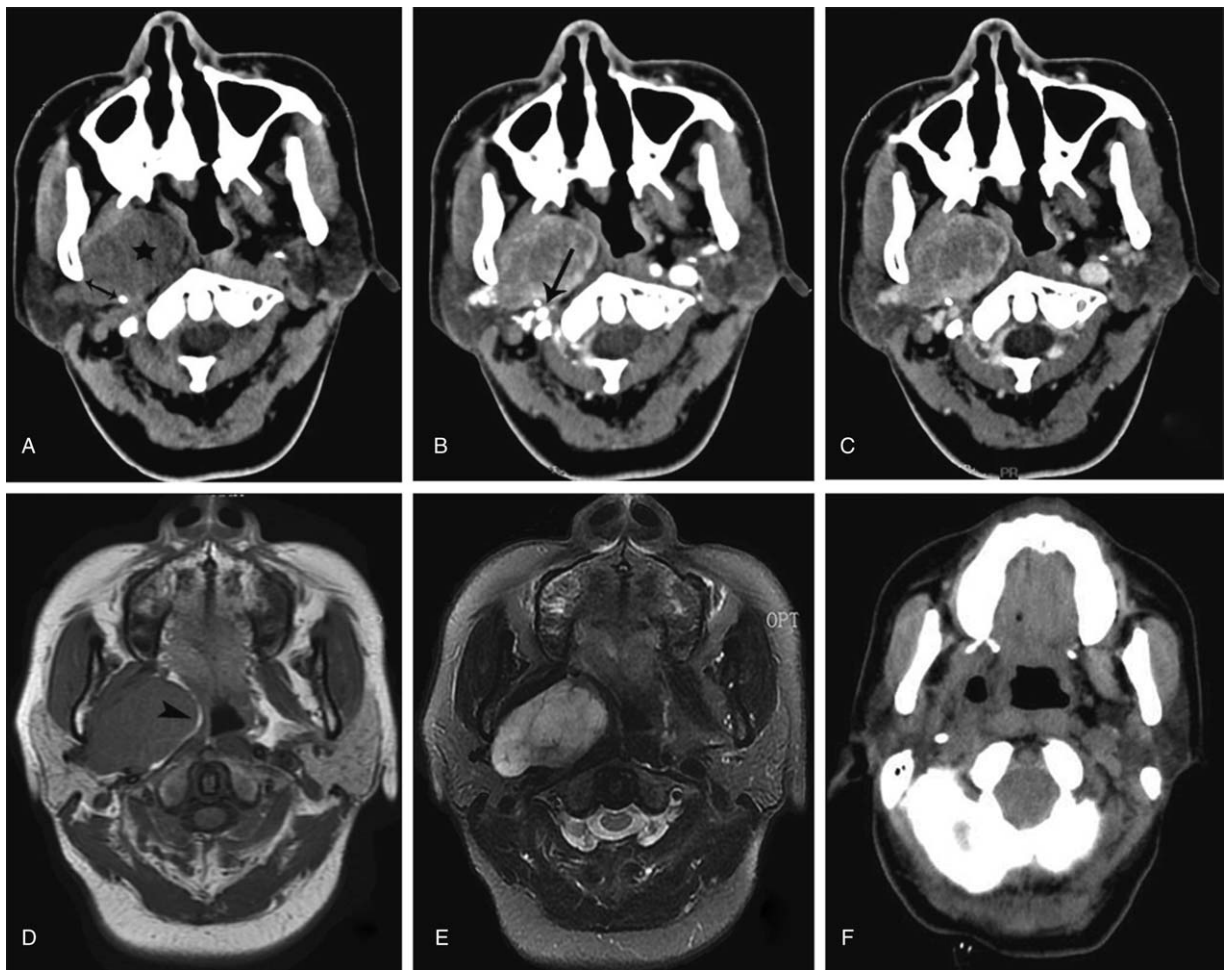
(A) Unenhanced computed tomography (CT) scan showed a well-defined mass measuring 60 × 40 mm in the right parapharyngeal space (PPS) (star). The stylomandibular tunnel (double-headed arrow) was widened due to the tumor. (B) The mass exhibited heterogeneous enhancement at the periphery of tumor in the early phase. The internal carotid artery was displaced laterally and posteriorly (arrow). (C) Enhancement of the mass decreased gradually in the later phase. (D) Noncontrast T1-weighted magnetic resonance imaging (MRI) showed a well-margined mass, which was isointense relative to muscle. A fat cap sign was visible at the anterior and medial side of the mass (arrowhead). (E) Noncontrast T2-weighted MRIs showed the mass was heterogeneously hyperintense. (F) Follow-up CT scan at 2 weeks after surgery showed a blurry right PPS with no sign of a residual lesion.
